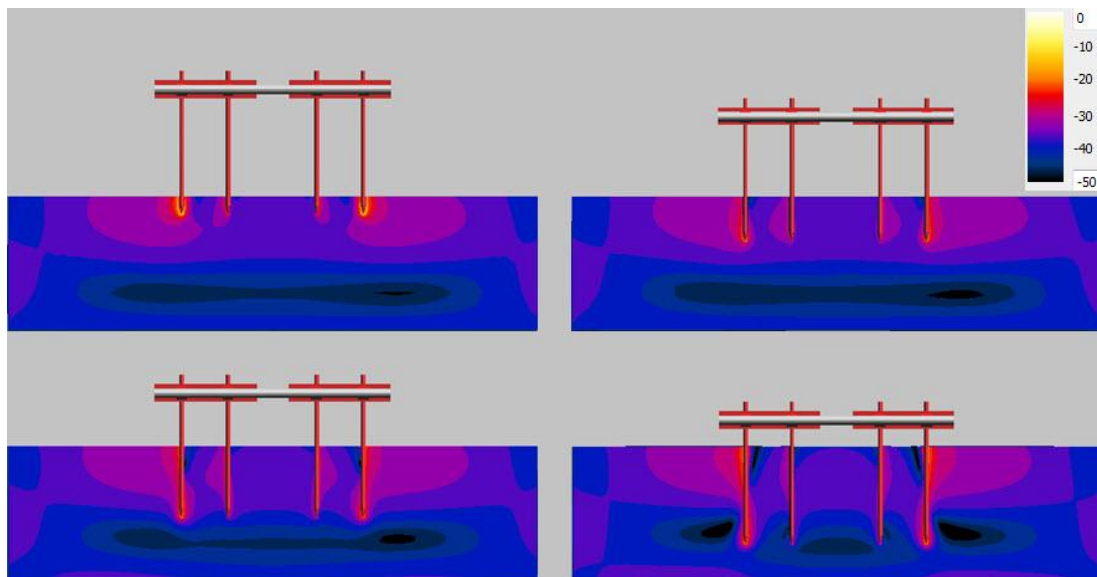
Power loss along the device pin with different insertion depth in 3-T MRI.
